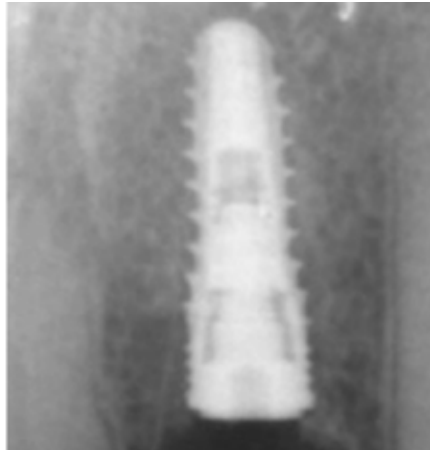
Radiograph of placed Implant and graft.
